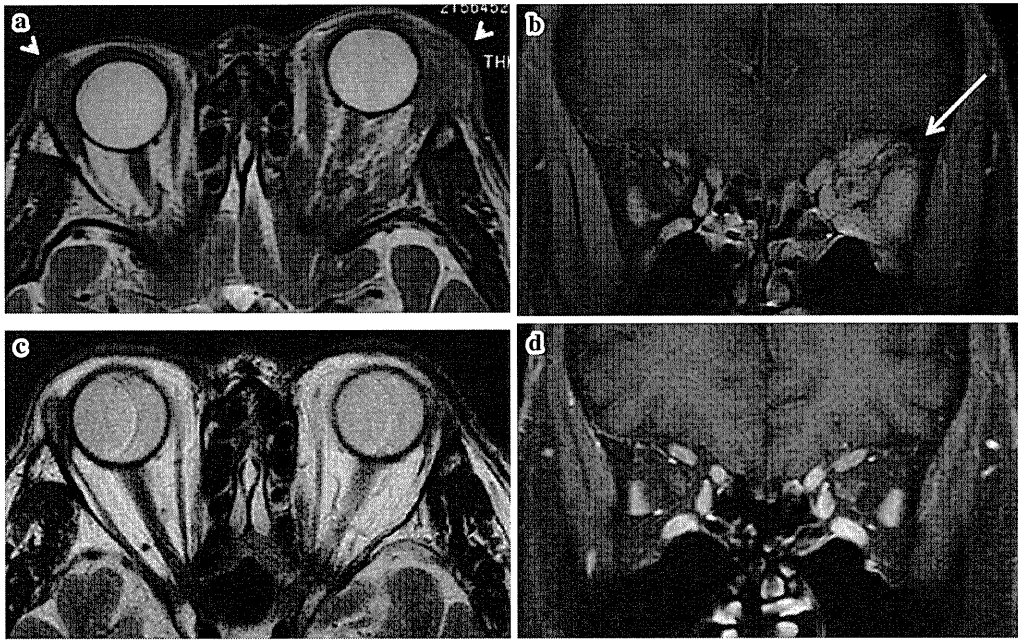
Magnetic resonance imaging of orbit reveals swelling of bilateral lacrimal glands (short arrow) (a, axial T2-weighted imaging) and an orbital floor pseudotumor (long arrow) (b, coronal T1-weighted fat-suppressed imaging). (c, d) These lesions improved markedly after steroid therapy.
